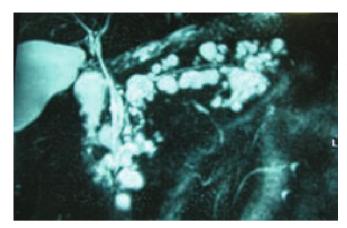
MRI in a 65year-old female patient with an intraductal papillary mucinous neoplasm of the entire pancreas
